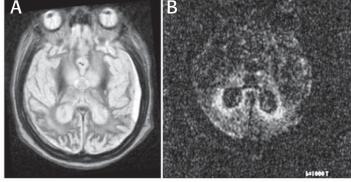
A. axial T2W shows diffuse significant atrophy of the brain and B. supranormal water diffusion on DWI sequence (b = 1000 mm2/s).
